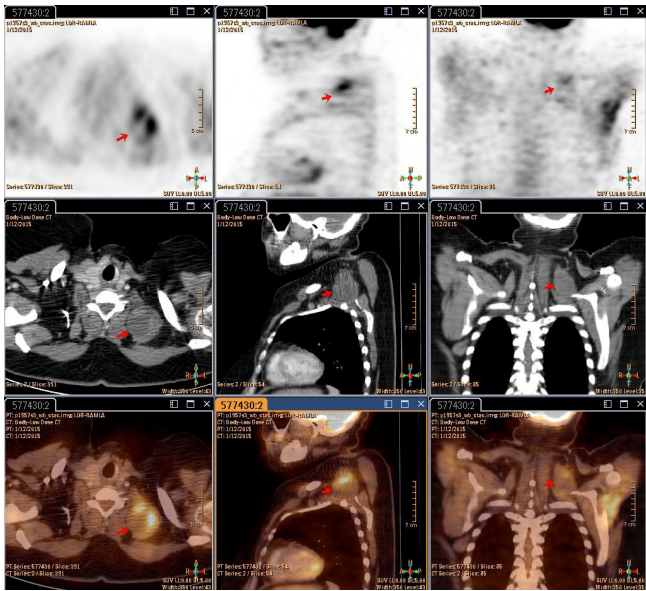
The heterogeneous 18F-FDG uptake at palpable mass in left SCM muscle.
